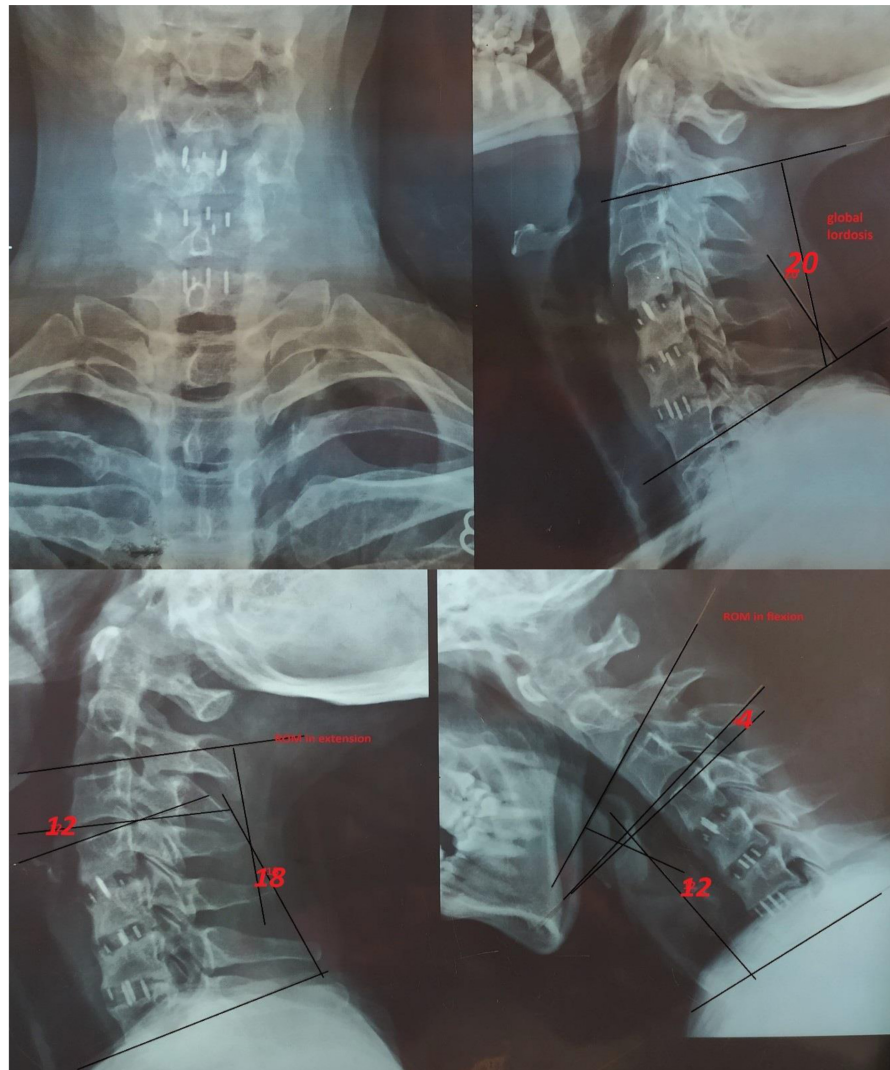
1 month Postoperative X-ray Cervical spine AP, lateral, flexion and extension views show that global lordosis was 20, global ROM reduced to 30 (18 for extension and 12 for flexion). Cranial ROM decreased to 18 (12 in extension and 4 in flexion).
